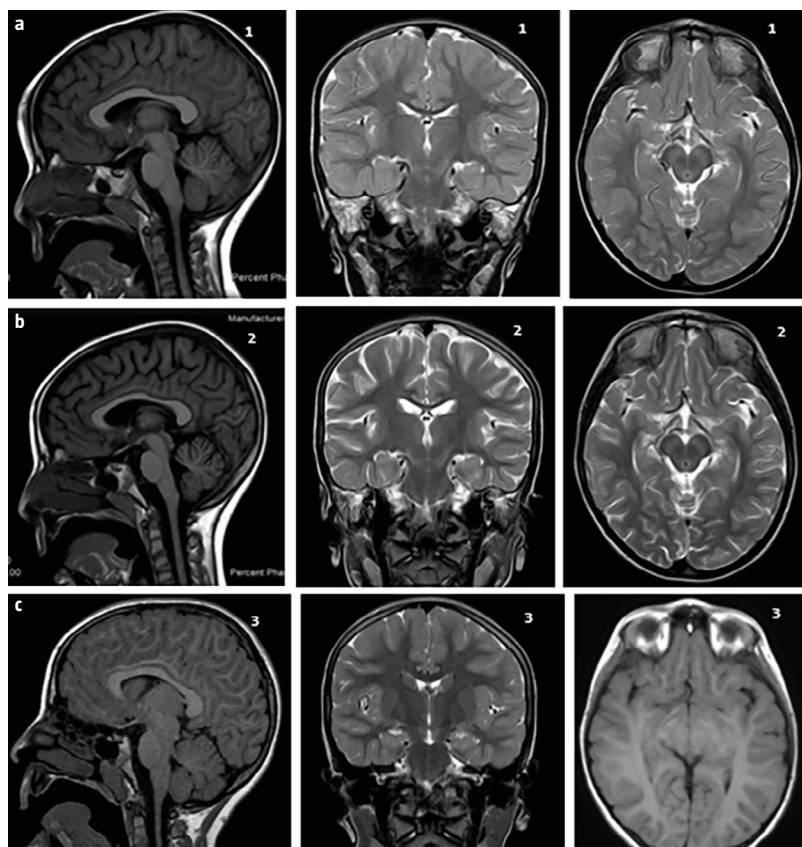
Magnetic resonance imaging of patient 2. a) Findings at baseline, showing no evidence of disease. b) Images revealing presence of brain pseudoatrophy. c) Images suggesting improvement of the cerebral volume loss obtained eight years after valproic acid dose reduction.
